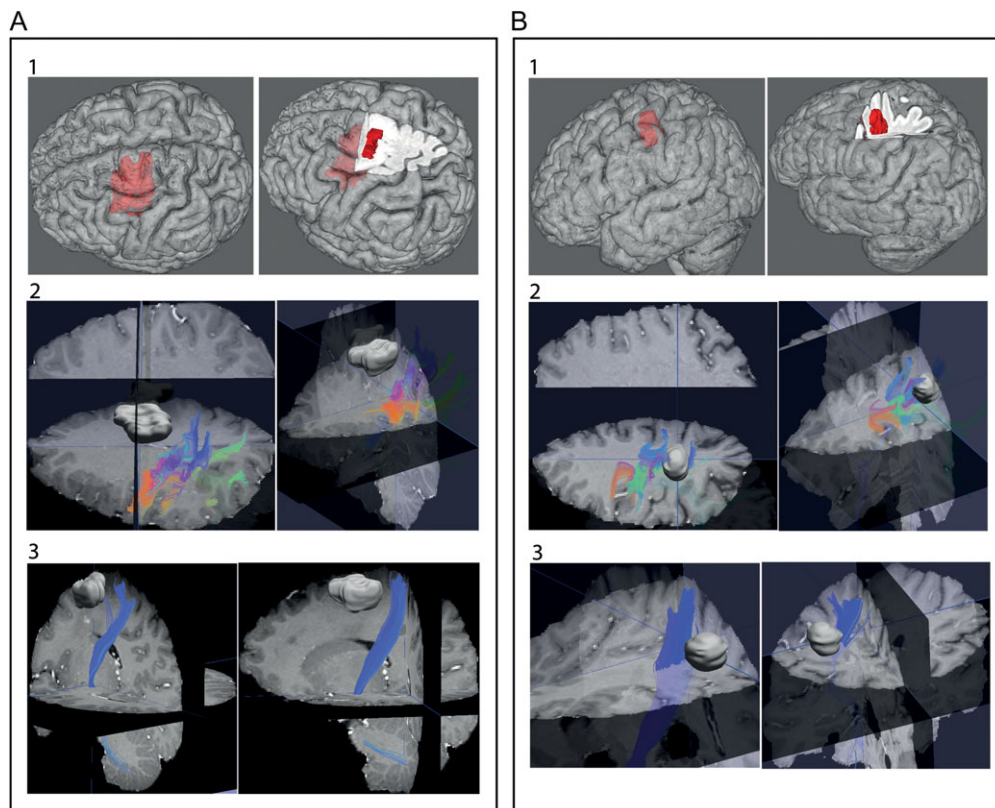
(A) Example of a patient included in the study. The tumor was located in the mesial area and did not affect the anatomy of the cortex within the central and precentral sulcus; (B) example of patient excluded from the study. The tumor located across the central sulcus affected the anatomy of the surrounding cortex. For both (A) and (B): panel 1) Anatomical localization of the tumor (in red). Tumor volume was computed on volumetric FLAIR MRI of the patient; in case (A) the posterior margin of the tumor did not reach the precentral sulcus, while in case (B), the tumor was within the central and precentral sulci; panel 2) relationship between fibers within the precentral area and the tumor. DTI reconstruction of the fibers running within the precentral sulcus. The different colors come from combined fractional anisotropy and directional maps. Colors indicate fiber direction as follows: red, left-right; green, antero-posterior; blue, superior-inferior. In case (A), the fibers are not contiguous to the tumor, but this was the case in patient (B). Panel 3) relationship between corticofugal fibers originating from M1 and located close to the tumor. This is based on a DTI reconstruction of the fibers connecting the cerebral peduncles with the M1 forearm-hand area. In case (A) descending fibers are not contiguous to the tumor, it was the case in patient B, displacing adjacent descending fibers.
